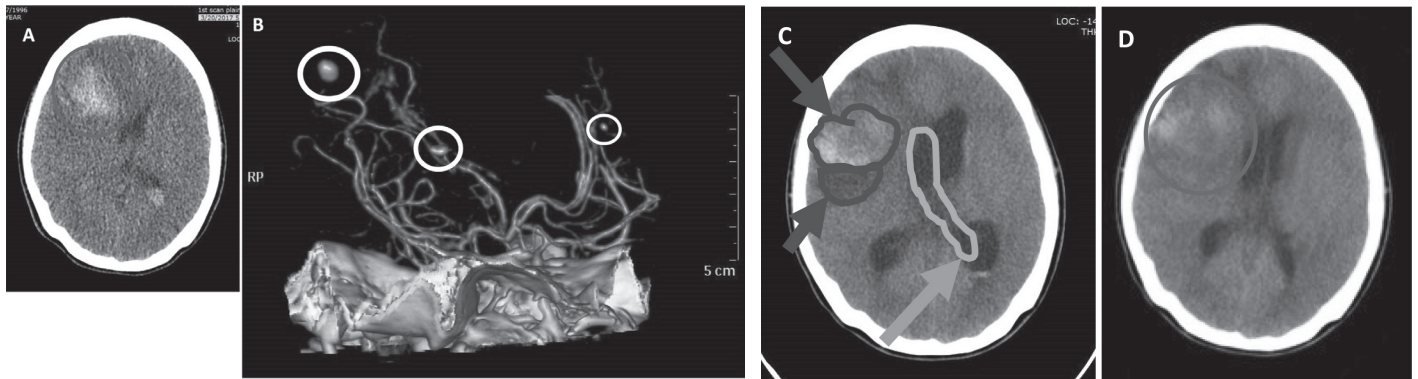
(A) Plain Cranial CT Scan on day of admission showed Parenchymal hemorrhage (14cc) involving the right frontal lobe with intraventricular extension, and resultant mild subfalcine herniation. (B) Sixteen days post-ictus, CT angiography revealed an acute to subacute parenchymal hemorrhage measuring approximately 13cc involving the right frontal lobe with intraventricular extension; multiple saccular aneurysms were noted. (C) Follow-up CT scan showed decrease in density and amount of the previously noted hyperdensity due to evolution of the hematoma in the right frontal lobe, now measuring approximately 9.33cc by CT volumetry. A new hyperdensity was noted posteroinferiorly in relation to the aforementioned hematoma, measuring approximately 8.0cc. (D) There is almost complete resorption of bleed in right frontal lobe and right ventricle, and marked decrease in the size of ventricles.
